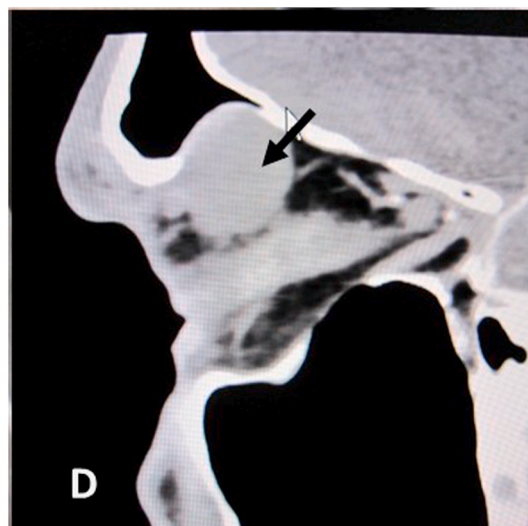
Sagittal view of orbital CT scan. The lesion is marked with black arrow.
